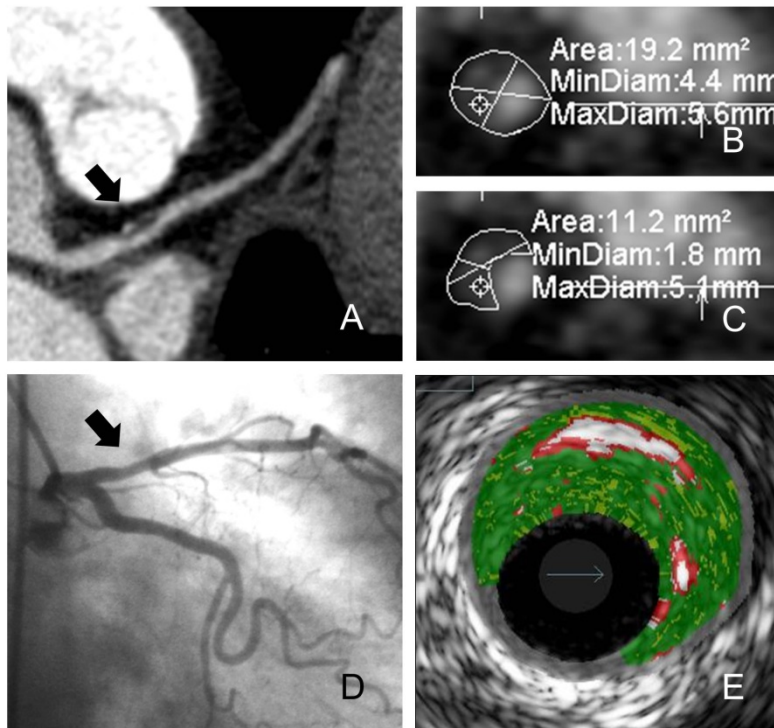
Underestimation of coronary plaque burden by ICA as compared to CTCA and IVUS. Panel A: CTCA curved multiplanar reconstruction of left anterior descending coronary artery (LAD) showing a mixed plaque (calcified and non-calcified plaque), arrow. Panel B and C: CT coronary angiography image showing cross sectional view of LAD at the sight of the mixed plaque with total vessel area of 19.2 mm and plaque area of 11.2 mm. Panel D: Invasive coronary angiography image of right anterior oblique view of LAD showing only mild stenosis in proximal LAD (arrow). Panel E: intravascular ultrasound image at the sight of lesion in LAD confirming large plaque burden (60%) consisting mainly of fibrotic tissue (green) and calcified plaque (white).
